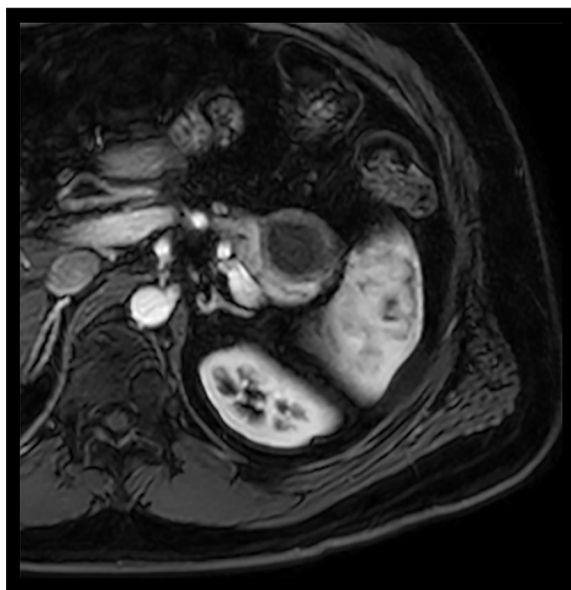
Follow up MRI at 6 months confirms a complete resolution of the aneurysmatic sac.
